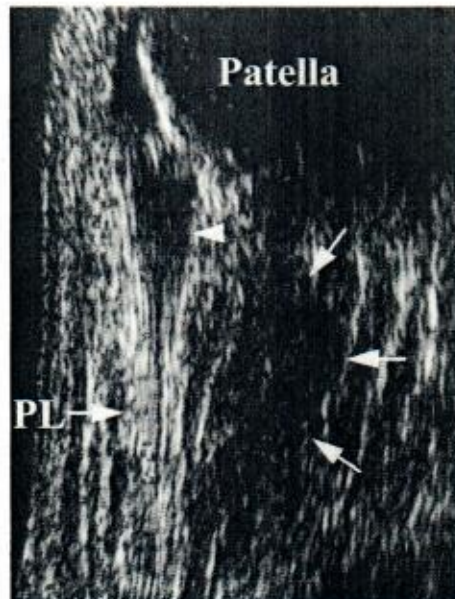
Jumper's knee. Ultrasonography with sagittal direction of sectioning of the anterior aspect of the attachment of the patellar ligament (PL) to the patella. There is disruption of fibers of the patellar ligament (arrowhead) and inflammatory changes are present in the fat pad of Hoffa (arrows). (Courtesy of L. Bolvig, MD, Aarhus, Denmark)
